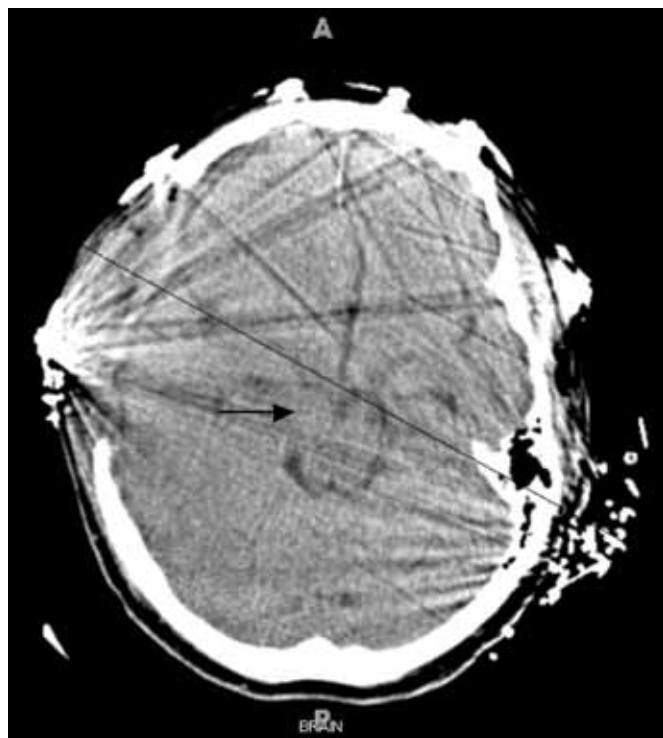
(Top Left) *Uncal herniation on initial head CT image.* (Top Right) *Duret hemorrhages of the midbrain tegmentum on a CT image of the same patient days later.* (Bottom Left) *Duret hemorrhages seen on MRI image.* (Bottom Right) *Duret hemorrhages and ischemic change seen on MRI image of the central midbrain.*
